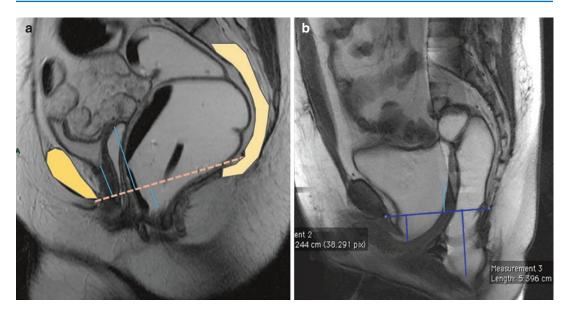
MRI defecography: Evacuation – patient with perineum descent, anterior, and posterior compartment. (a) Sagital plane at rest. (b) MRI defecography with 'pelvic floor descent
